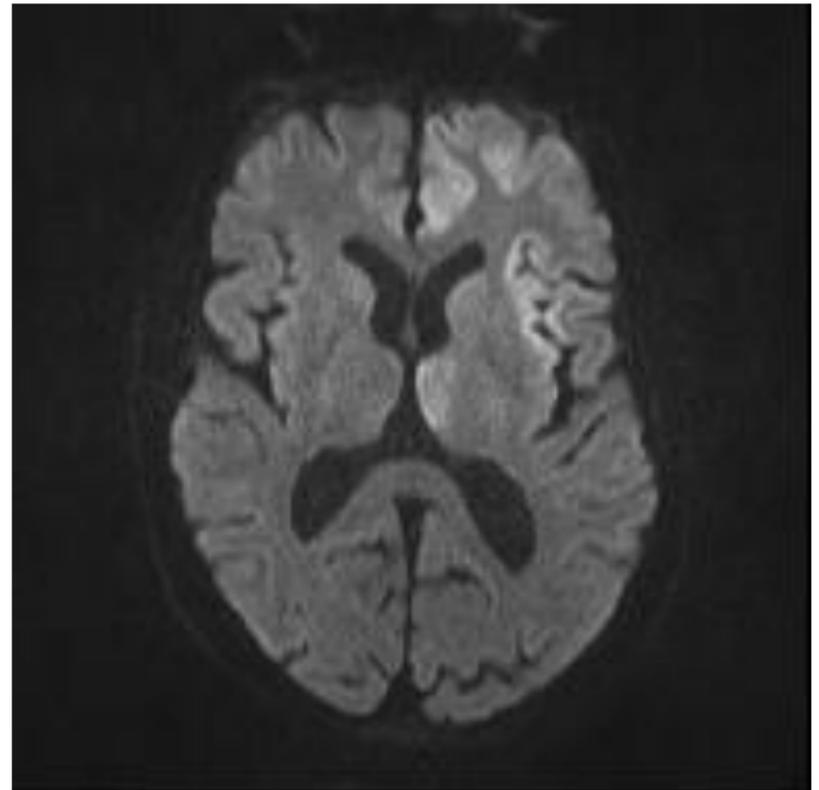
Brain MRI DWI hyperintensity in left fronto-insular cortex and thalamic nuclei.
